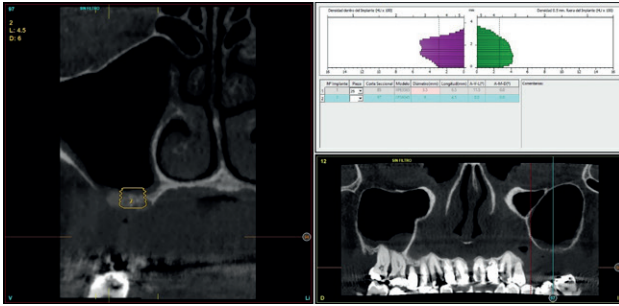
Cross-sectional CBCT planning image showing the limited residual ridge height and the planned placement of a 4.5-mm-long, 6-mm-diameter implant.
